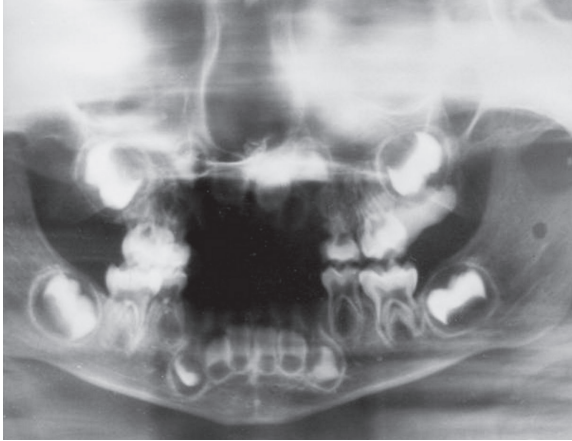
Tooth development data from radiographs are used in the estimation of the biological age of infants – three years old boy.
